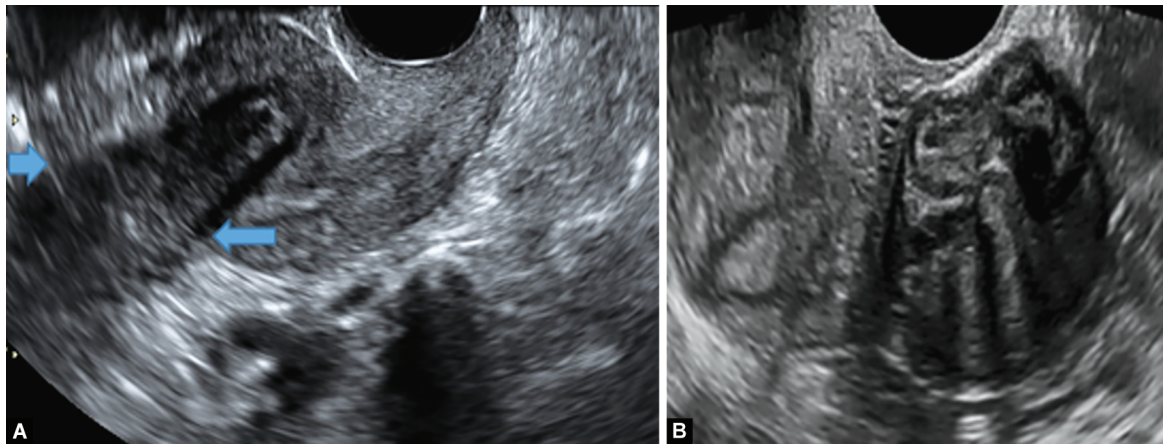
(A) 3D ultrasound image showing oval fibroid with calcification, large subserosal fibroid with fan and edge shadows in the rounded fibroid (arrow) 2D; and (B) 3D ultrasound
